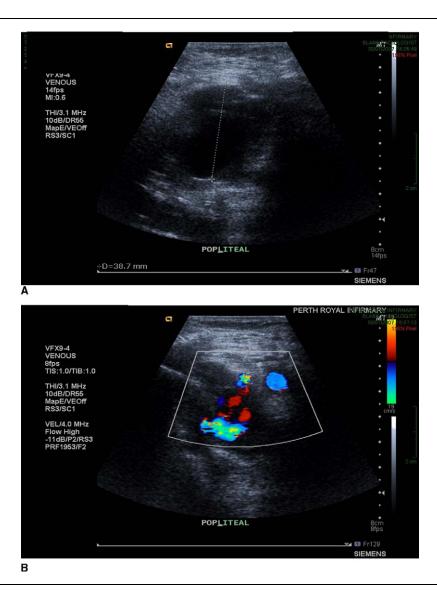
Duplex scan of left popliteal fossa which revealed a 3.9 mm pseudoaneurysm on B mode ultrasound (A) with the classical color flow characteristics (B).
